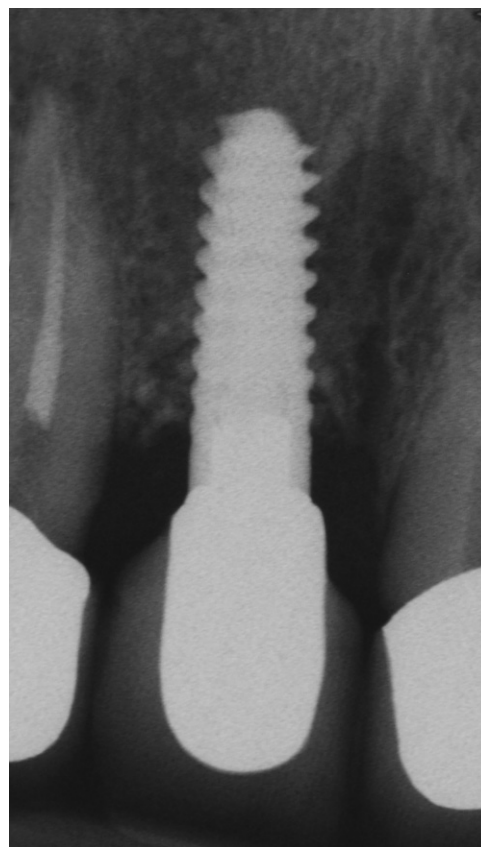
Radiographic examination of bone tissue, after 1-year follow-up.
